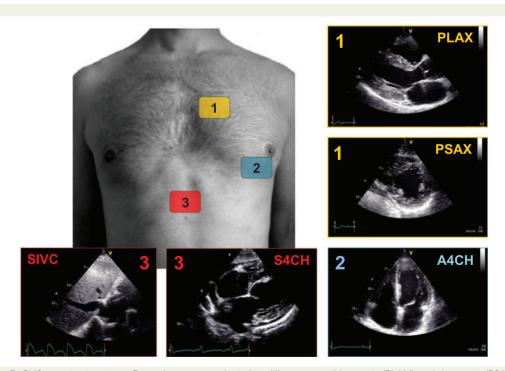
Figure I Basic FoCUS examination views. From the parasternal window (1), parasternal long-axis (PLAX) and short-axis (PSAX) views can be obtained; apical 4-chamber view (A4CH) is obtained from the apical window (2); subcostal inferior vena cava (SIVC) and subcostal 4-chamber (S4CH) views can be obtained from subcostal window (3).
